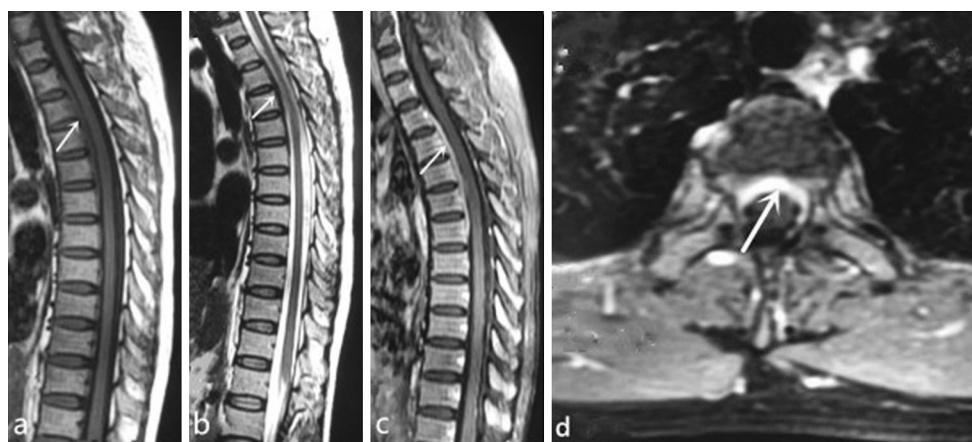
Initial MR imaging. A dural-based mass in the anterior aspect of the spinal canal extending from T2 to T6 level which is uniform signal intensity in sagittal T1-weighted image (a), low signal intensity in sagittal T2-weighted image (b) and enhanced in sagittal
